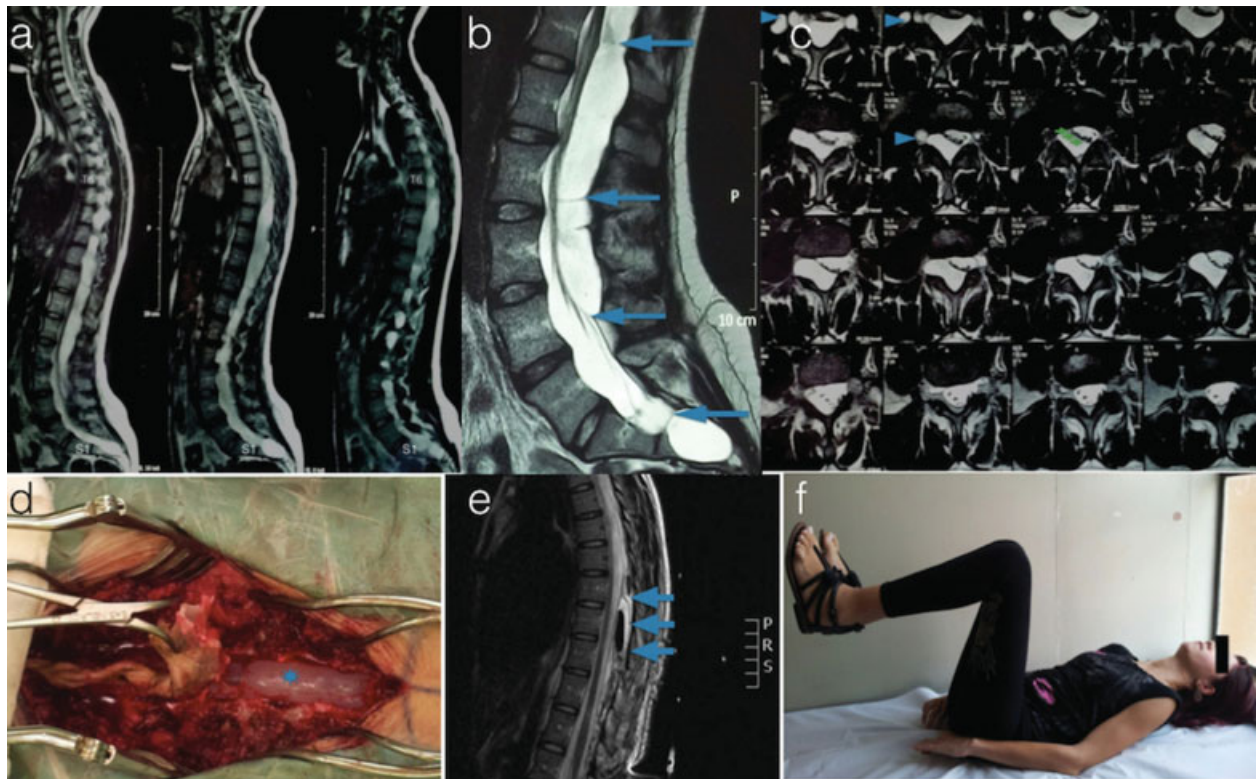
(a) Sagittal sections of MRI T2 showing arachnoid cyst from T6 to S1. (b) Sagittal section of MRI T2 showing in detail the cyst septa by the blue arrows. (c) Axial sections of MRI T2 showing extramedullary arachnoid cyst compressing the spinal cord anteriorly and to the left as shown by the green arrows. Arachnoid cyst insinuating the intervertebral foramen as shown by the blue arrows. (d) Laminotomy showing septate cystic extradural lesion. Blue mark corresponds to the cyst. (e) Sagittal section of MRI T2 showing postoperative residual lesion on T6 and T7 (blue arrows) but with satisfactory spinal decompression. (f) Patient with improvement in strength from 1/5 to 4/5 at 15th postoperatively.
